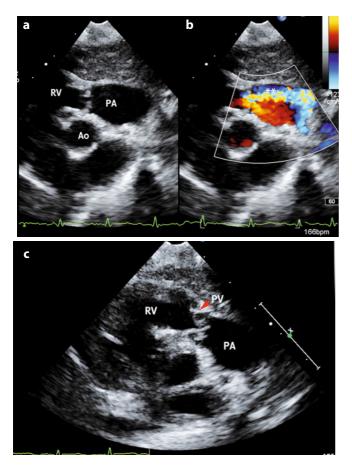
Two dimensional echocardiogram in newborn with severe pulmonary valve stenosis. a A parasternal right ventricular outflow tract view demonstrating a systolic doming of the pulmonary valve leaflets. b Two-dimensional color Doppler echocardiogram (parasternal long axis) demonstrating a central jet (*asterisks*) across the pulmonary valve. The pulmonary trunk is dilated. *Ao* Aortic valve; *RV* right ventricle. c Thick-ened pulmonary valve cusps (*arrow*)
